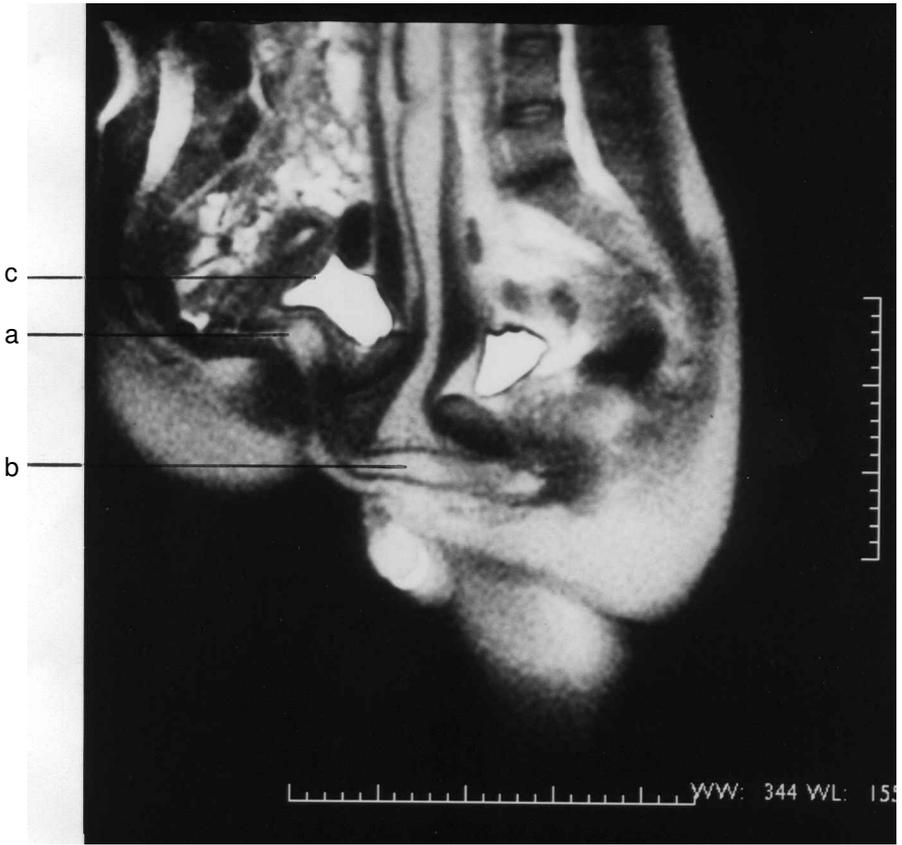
MRI photograph of second session, following penetration, showing penis (gland) with high signal in T2 weighted sequence in the anterior cul-de-sac (a), penis (perineal part) (b), and female bladder (c).
